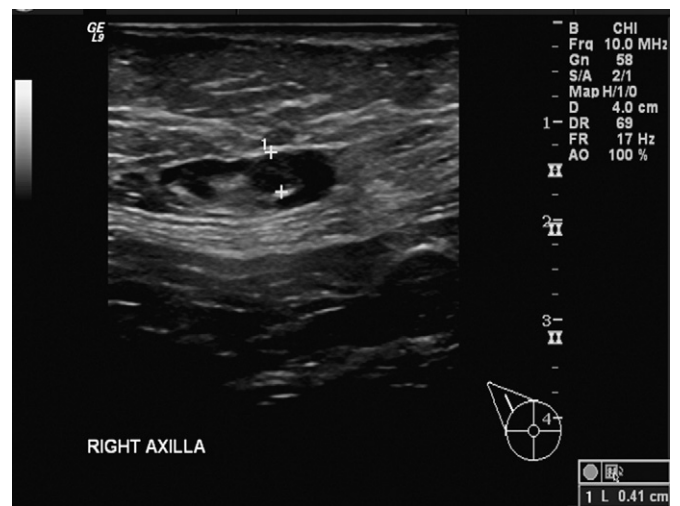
Sagittal ultrasound image, showing an axillary node with cortical thickening of more than 3 mm. A 54-year-old patient with known breast cancer. Biopsy results proved breast malignancy involvement of lymphoid tissue.
